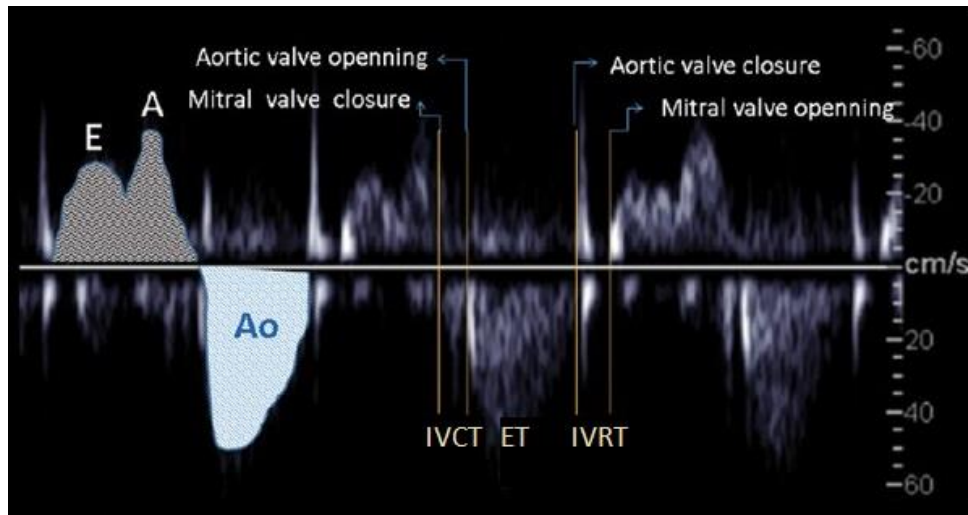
Mitral biphasic inflow (E and A waveforms) and aortic outflow (Ao waveform) in a spectral Doppler image. Time intervals include: IVCT, ET, and IVRT – Modification from [51]
